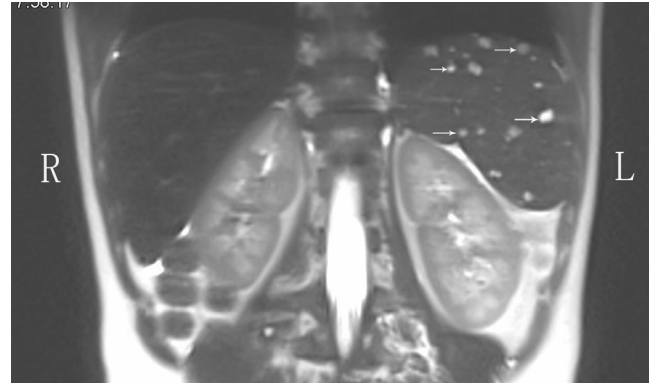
Coronal upper abdominal T2-weighted magnetic resonance image showing multiple microcysts (*arrows*) in the spleen, which implied the generalized lymphatic anomaly (GLA).
